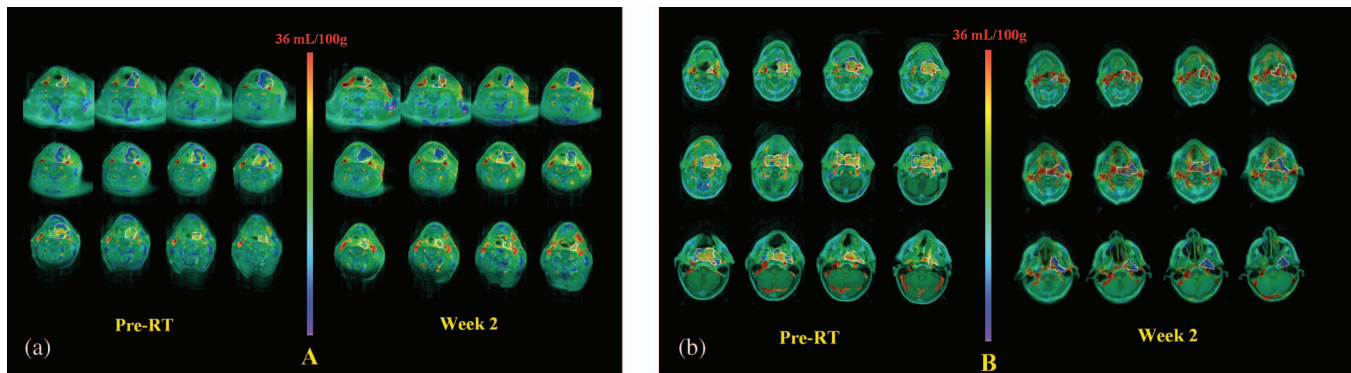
Two representative examples of the subvolumes of the primary GTVs with low BV, pre-RT and at week 2. BV maps are color-coded and overlaid on post-Gd T1-weighted images. White contours: primary GTV; blue color: the subvolumes of the GTV with low BV. (a) A local failure case with the whole GTV of 61.4 ml and the subvolume of the tumor with low BV of 28.6 ml pre-RT (left); and 44.8 ml, 20.9 ml, respectively, at week 2 (right). (b) A local control case with the whole GTV of 97.5 ml and the subvolume of the tumor with low BV of 16.5 ml pre-RT (left); and 52.3 ml, 17.4 ml, respectively, at week 2 (right).
